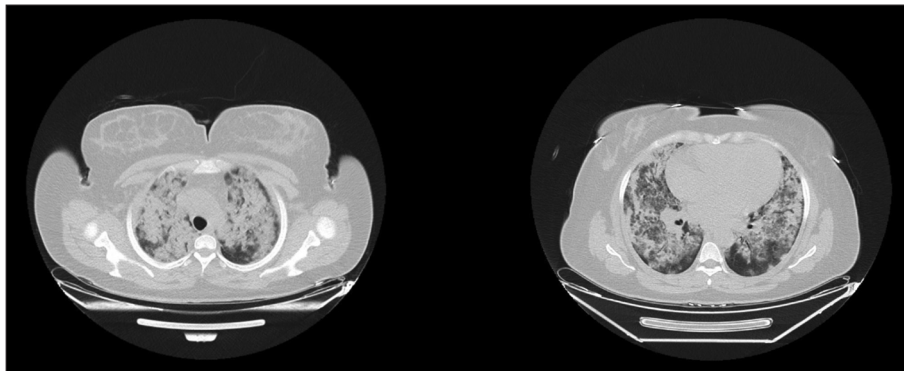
Follow-up chest computed tomography scan on the 13th postoperative day.
